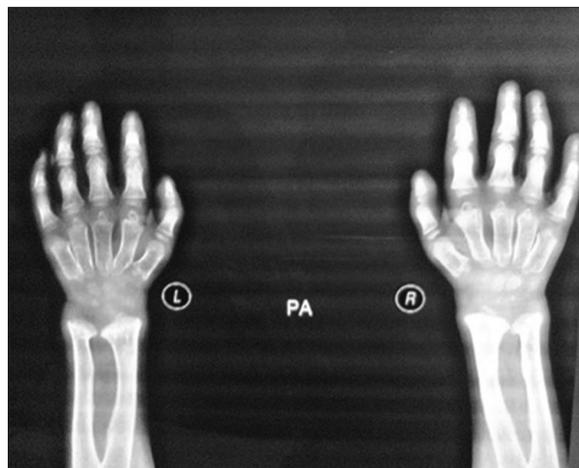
Bone radiographs of the patient showed evidence of severe skeletal dysplasia with bone enlargement, irregular shape, and bowing of bones
